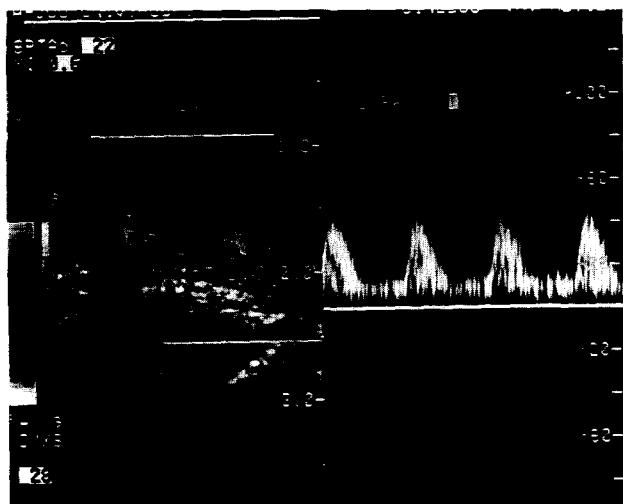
Follow-up Doppler shows patent well-pulsating popliteal artery.
